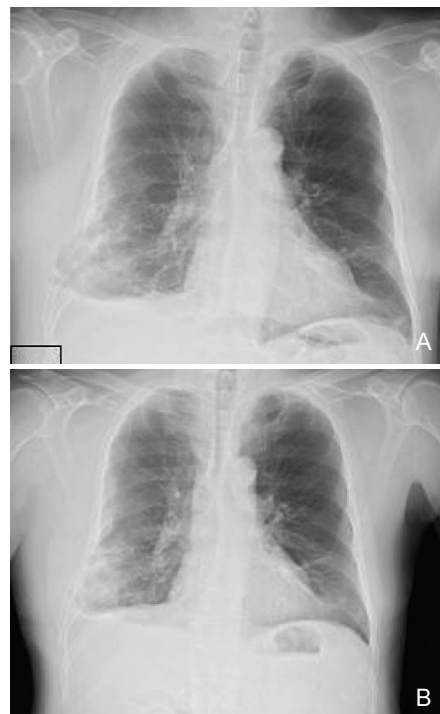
A: The third chest plain film, 2 weeks after noting the initial lung hernia. The herniated lung parenchyma was smaller when compared with the previous computed tomography image. B: The fourth chest plain film, 3 weeks after noting the initial lung hernia, in which regression of the lung hernia was seen.
